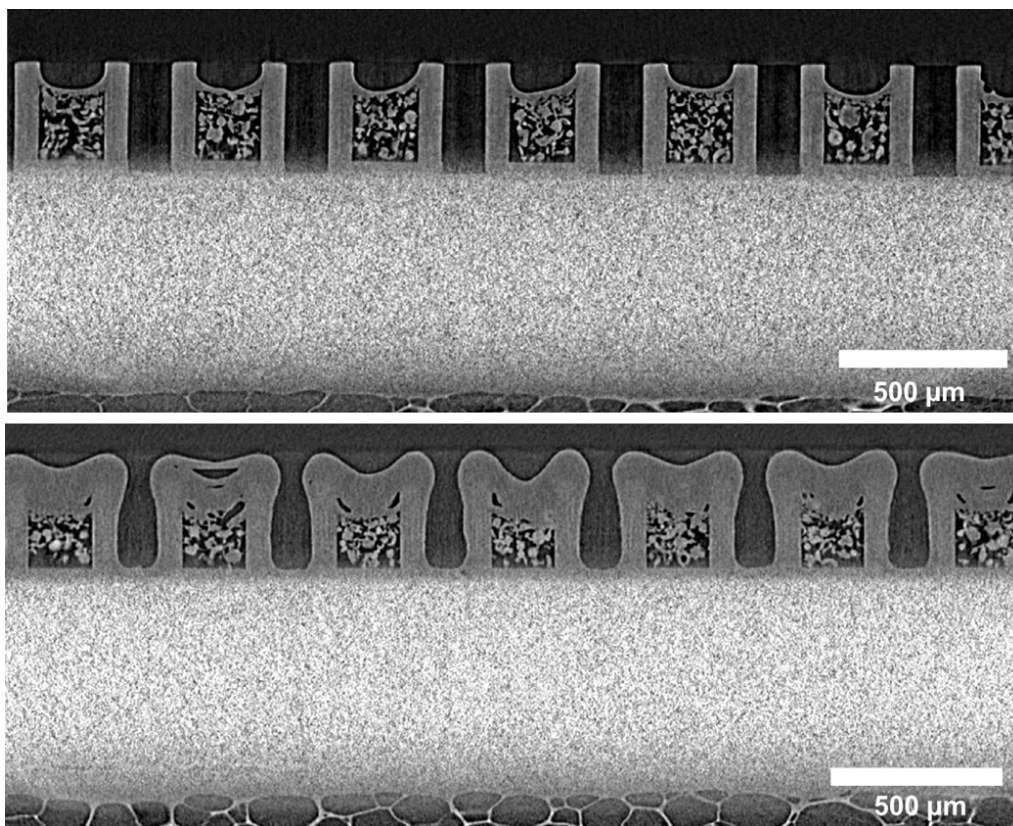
X μ CT images of an array of MCs filled with PVP K10 and loaded with ketoprofen by means of scCO₂ on the top, the same loaded MCs coated with a pH sensitive coating on the bottom. Figure taken from^[16].
